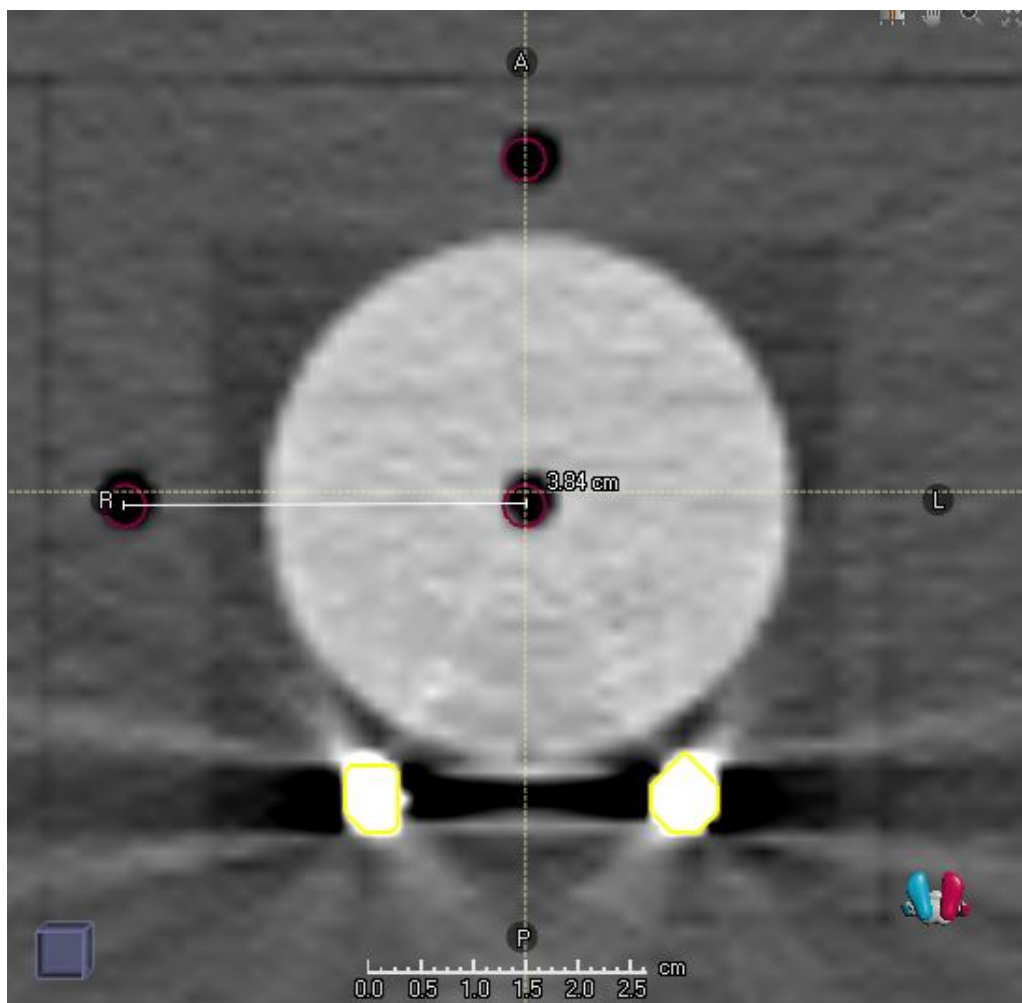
Distance measured between the central IC hole and lateral IC hole on the virtual model of MattL. Expected distance between these IC holes based on actual measurement was 3.8 cm. Note: The resolution of the CT image limited the centering of ROIs on the IC holes.
